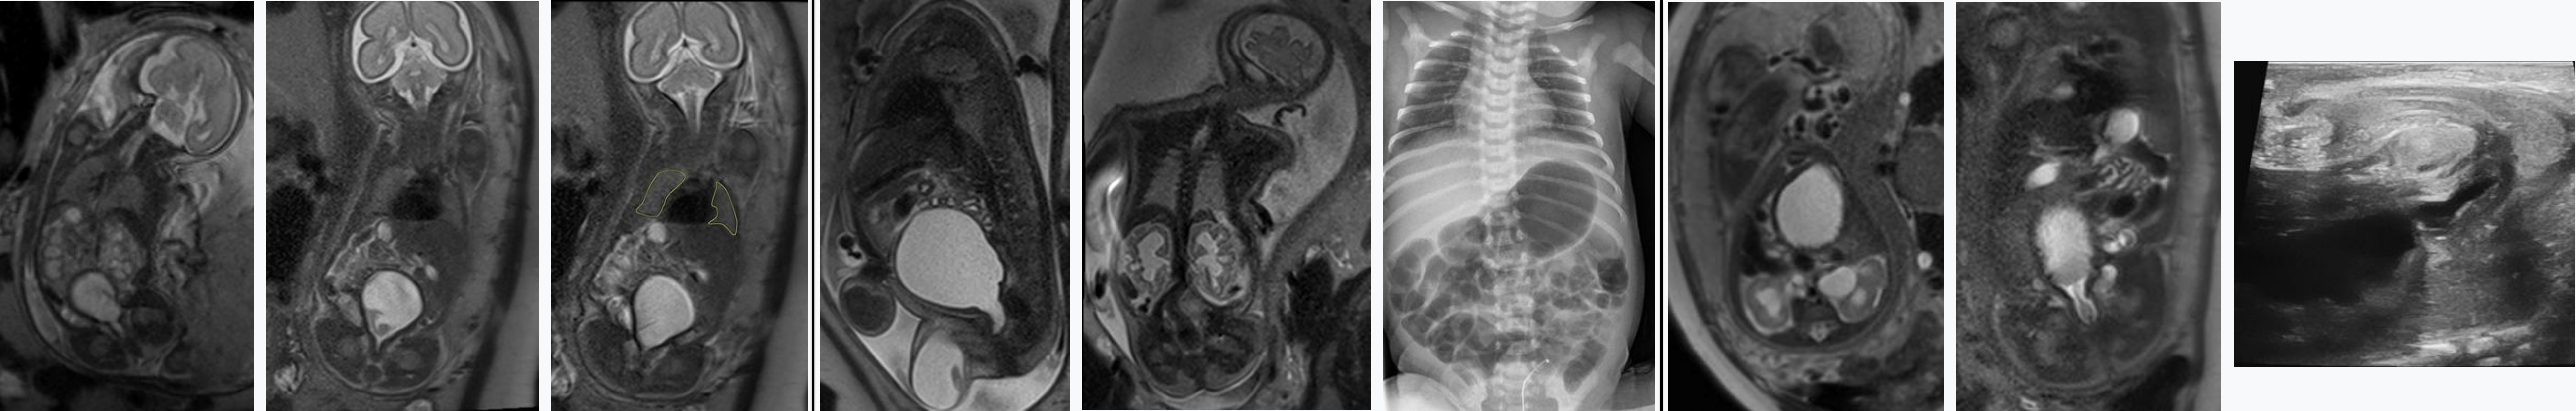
Case 1: Coronal T2-weighted fetal MRI demonstrates megacystis, bilateral hydroureteronephrosis, and renal parenchymal thinning, hypoplastic lungs, reduced amniotic fluid.
